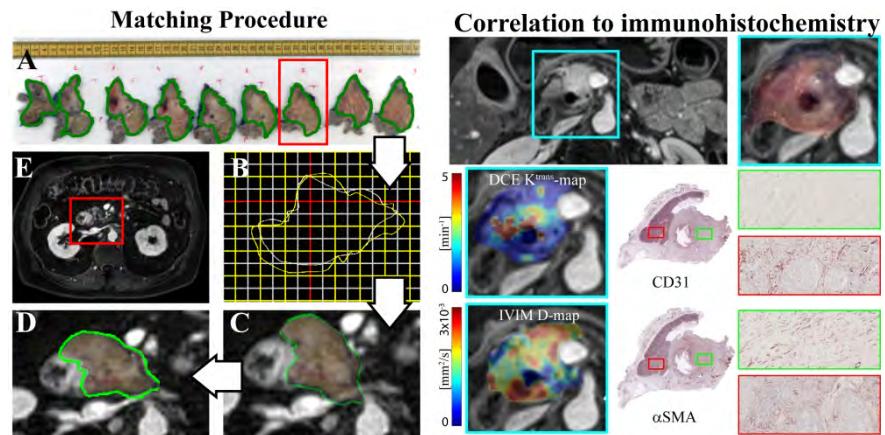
Matching procedure: A. Tissue slices with drawn contours; B. Orientation of adjacent contours; C. Rotation and translation of tissue slice projected on MRI; D. Final match of tissue slice to MRI; E. Reference anatomical MRI
